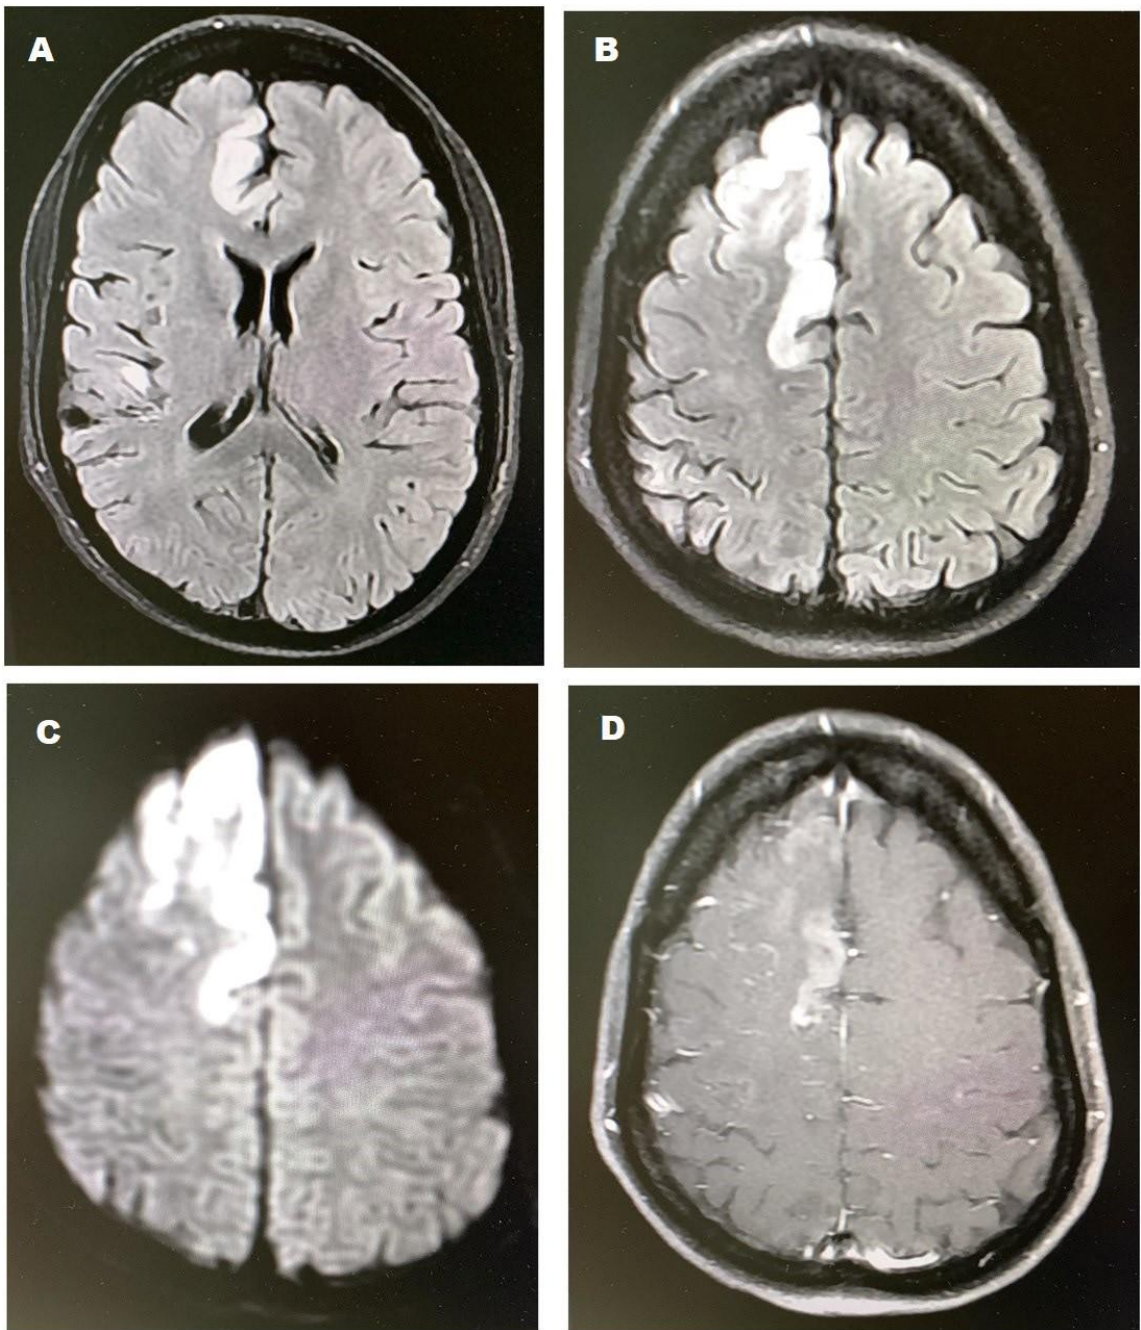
Magnetic resonance imaging of the brain showing hyperintense cortical lesions in FLAIR (A and B) with diffuse restriction (C) and focal enhancement of medium contrast medium (D) in high convexity, in the right superior frontal gyrus, left pre-central gyrus and middle frontal gyrus height on the right.
